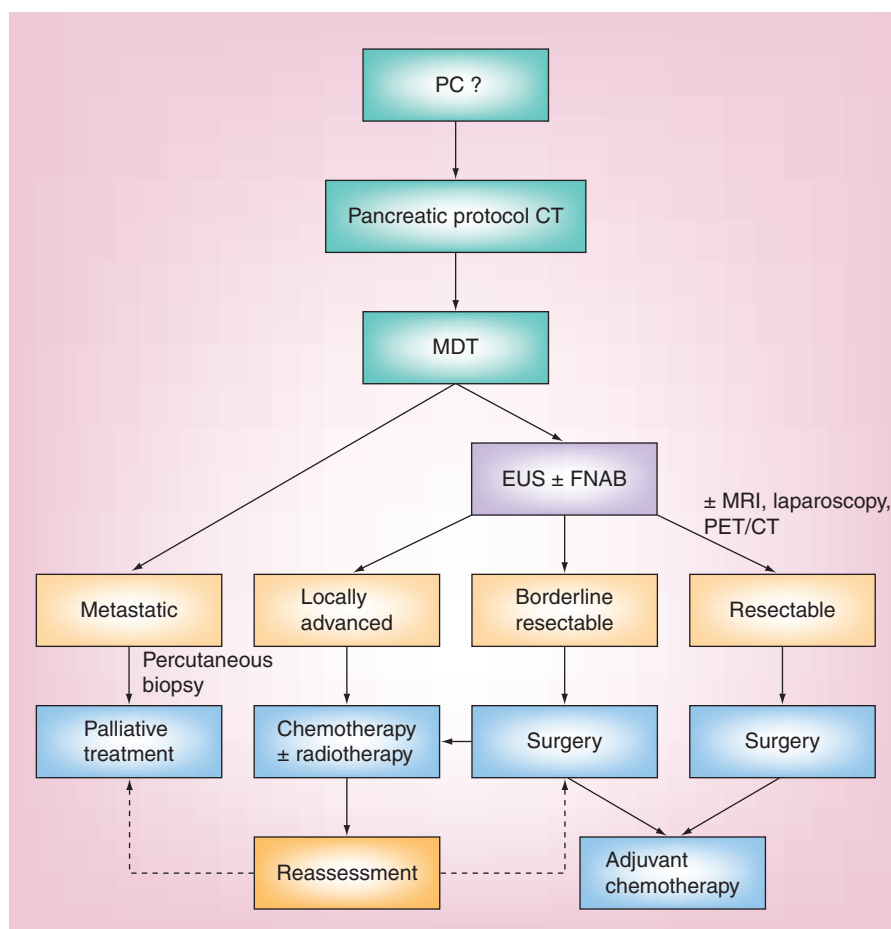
Suggested algorithm for the management of patients with suspected pancreatic cancer demonstrating the role of endoscopic ultrasound.
